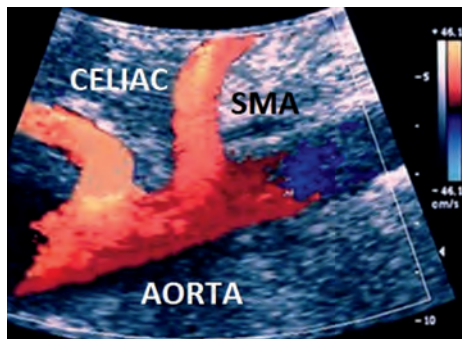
Color flow Doppler image using a low-frequency transducer in the longitudinal (sagittal) approach demonstrates the celiac artery followed by the superior mesenteric artery (SMA) branching off the aorta. Courtesy of Steve Bernhardt, BS, RDMS, RVT, RPhS.
